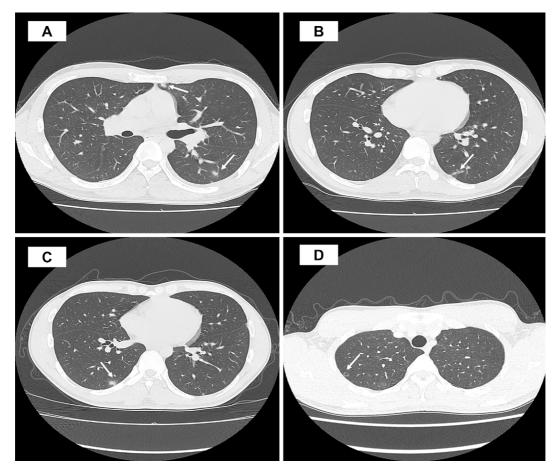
Chest computer tomography showing progressive multiple nodular shadows in both lungs (arrow) at 7 months before admission (A), 6 months before admission (B), and 1 month before admission (C). Contrast-enhanced computed tomography on admission revealing resolution of the bilateral pulmonary nodular shadows (D).
